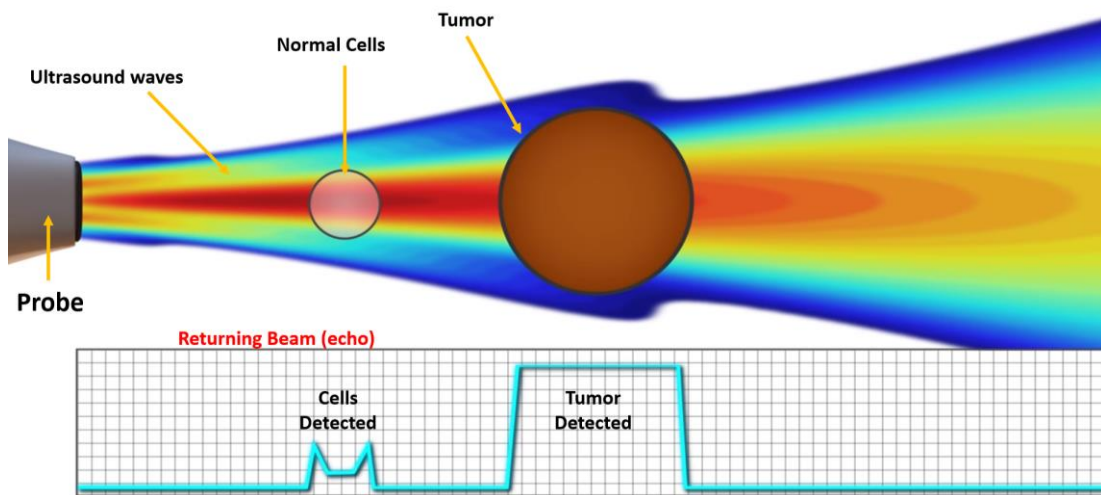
Tumor detection using ultrasound.
